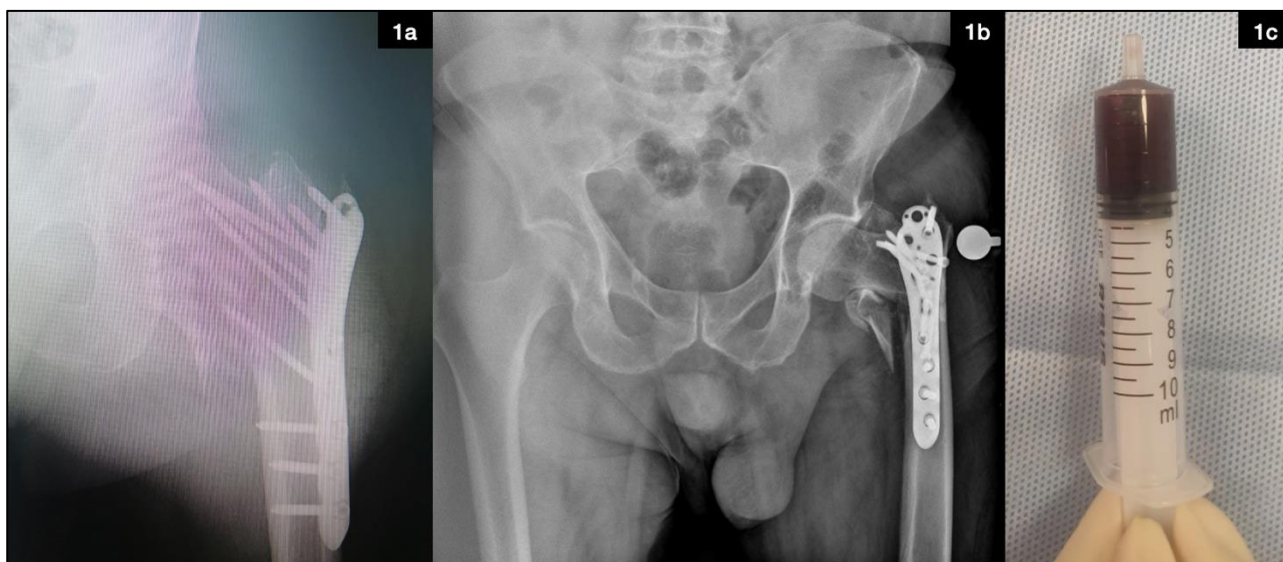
Postoperative X-rays showing plate and screw fixation (1a), implant failure and loss of reduction on Day 18 (1b), and left hip joint aspiration material (1c).
